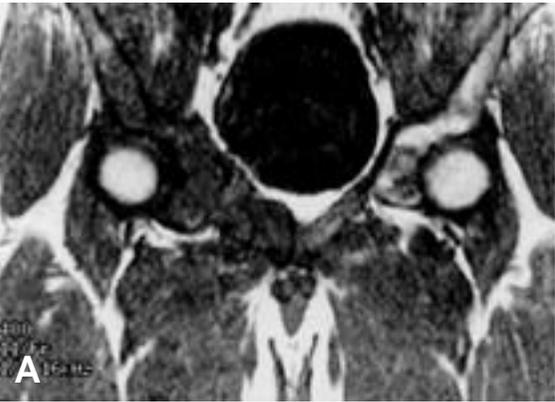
T1-weighted coronal image shows diffuse low signal intensities.
